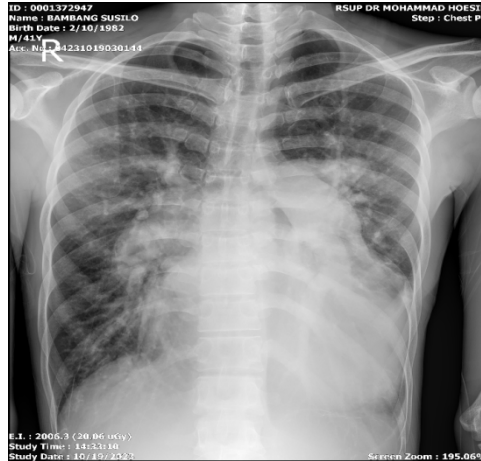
Chest X-ray, October 19, 2023
